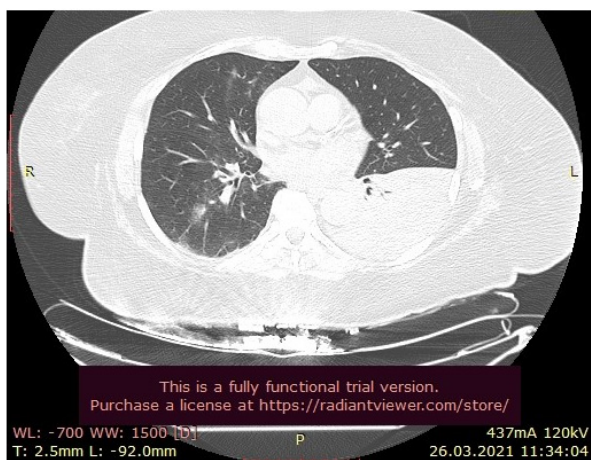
CT thorax in 69 old female symptomatic patient with Covid-19 pneumonia.
